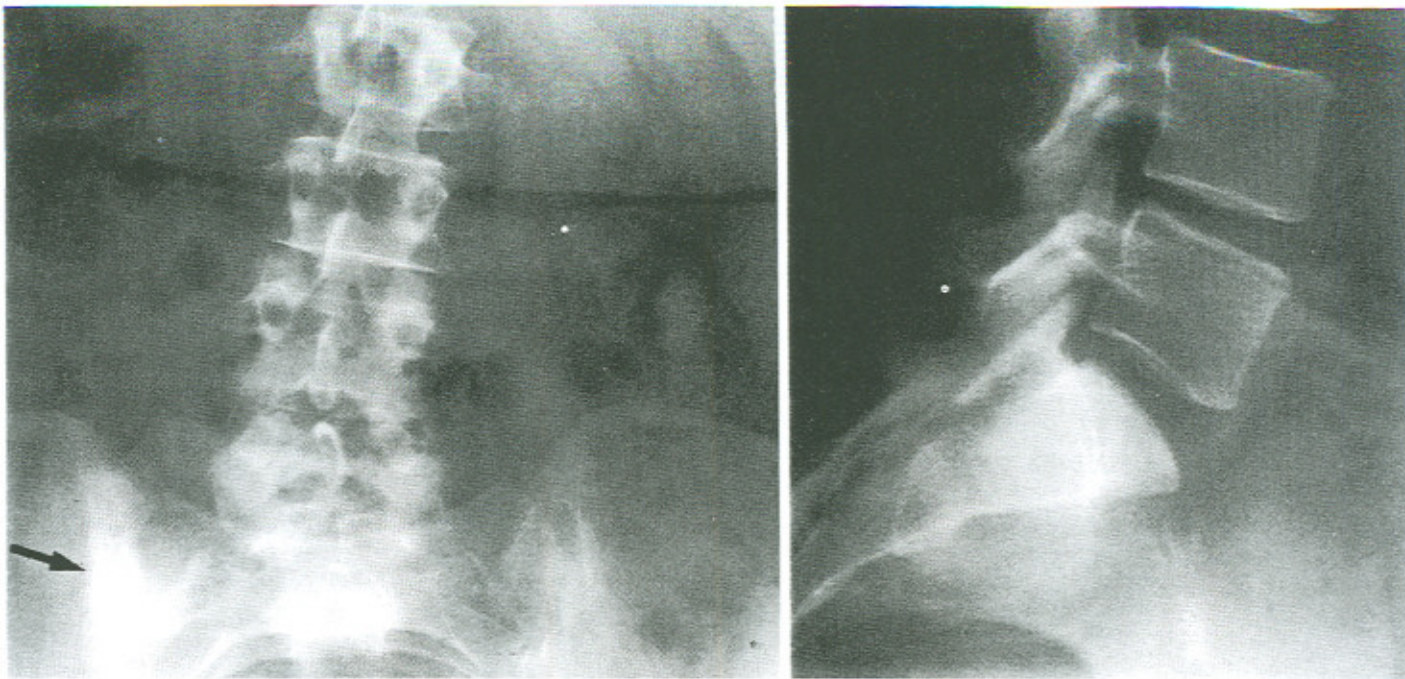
Radiographs (AP and lateral) of a 39-year-old female (case one), taken four months after the onset of left-sided sacroiliac (SI) joint pain. Note the sclerotic changes around the left SI joint (arrow).
